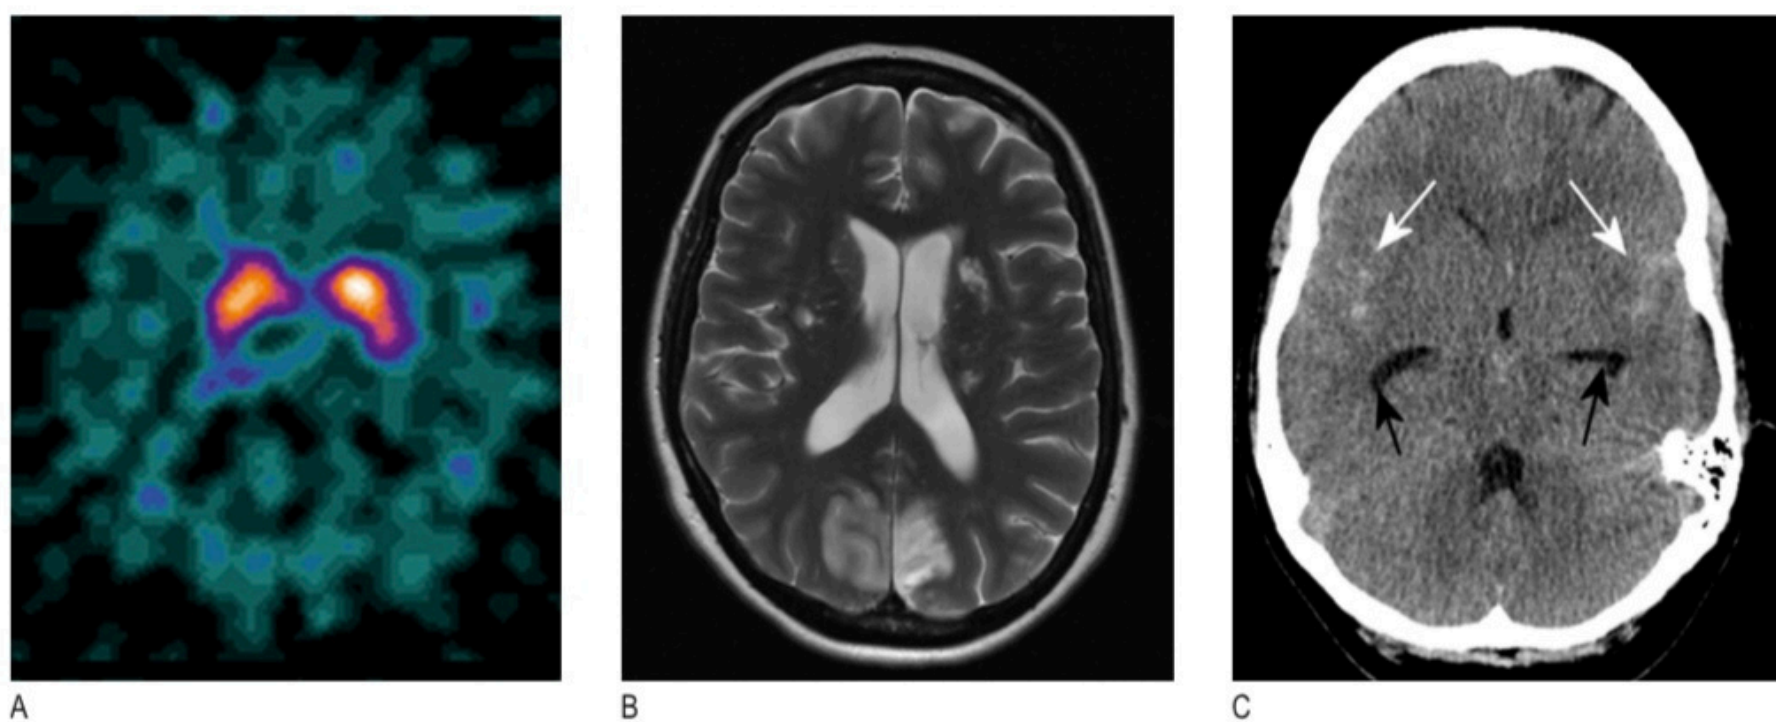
Imaging of the head. A DaTscan showing uptake of tracer (dopamine receptors) in the basal ganglia on cross-section of the brain. B Magnetic resonance scan showing ischaemic stroke. T2 imaging demonstrates bilateral occipital infarction and bilateral hemisphere lacunar infarction. C Unenhanced computed tomogram showing subarachnoid blood in both Sylvian fissures (white arrows) and early hydrocephalus. The temporal horns of the lateral ventricles are visible (black arrows).
